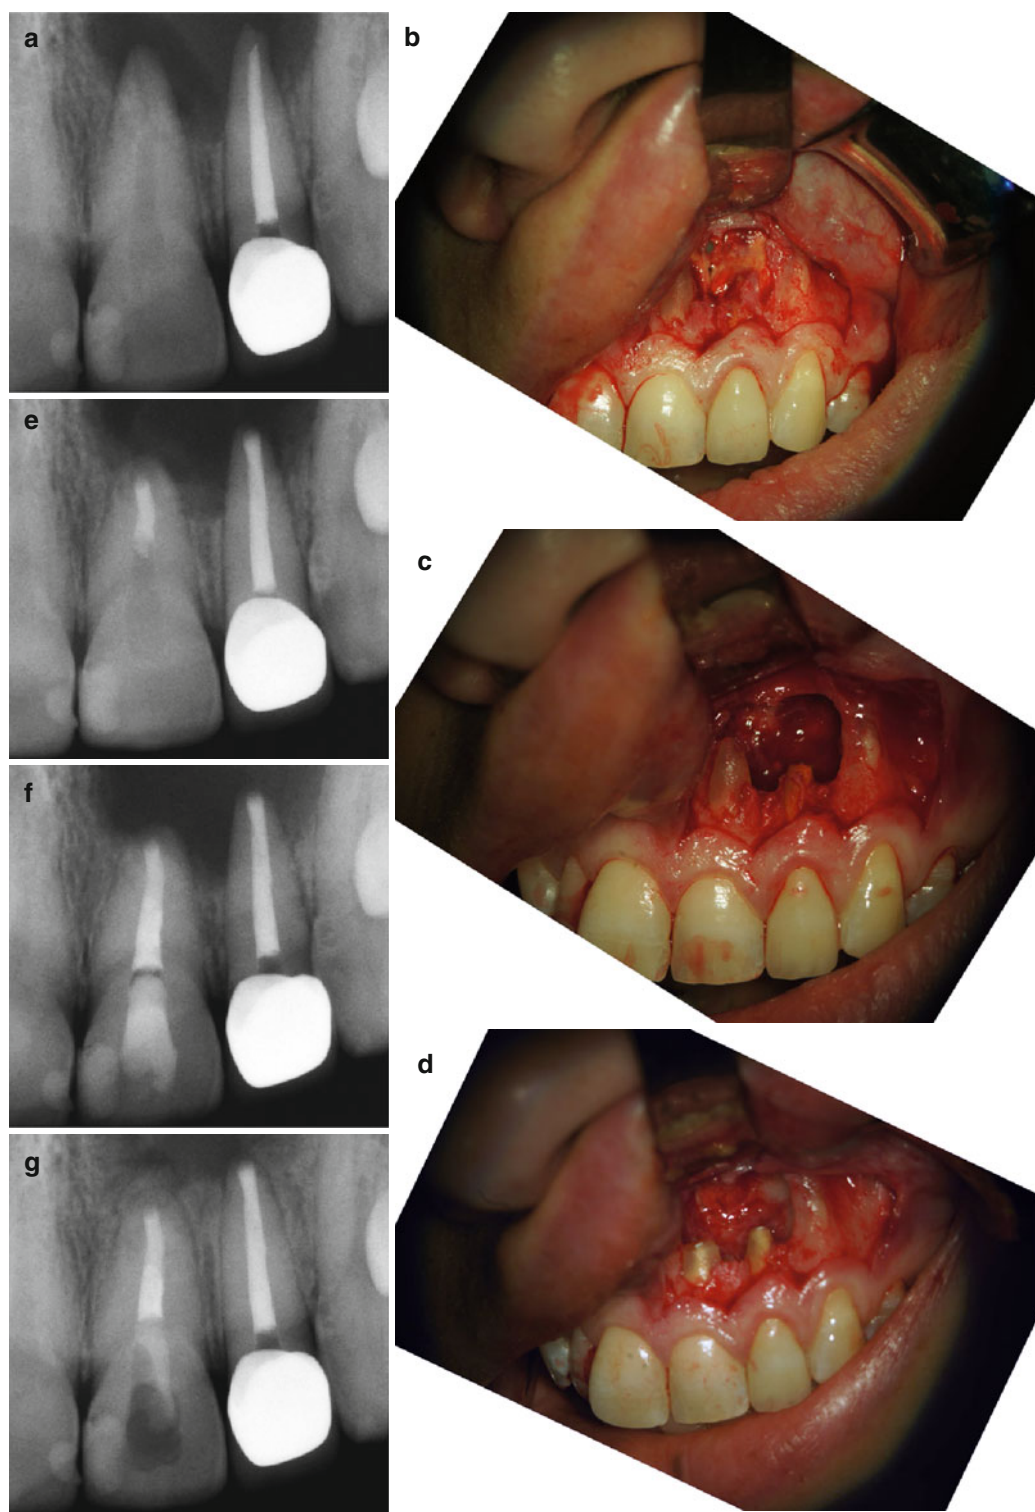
A large periapical lesion related to the second maxillary incisor, the first incisor tested vital. (a) Preoperative radiograph. (b) Intraoperative photograph following flap elevation, a large osseous defect is exposed. (c) Following curettage of the granulation tissue, the apex of the first incisor is exposed, and its neurovascular bundle
